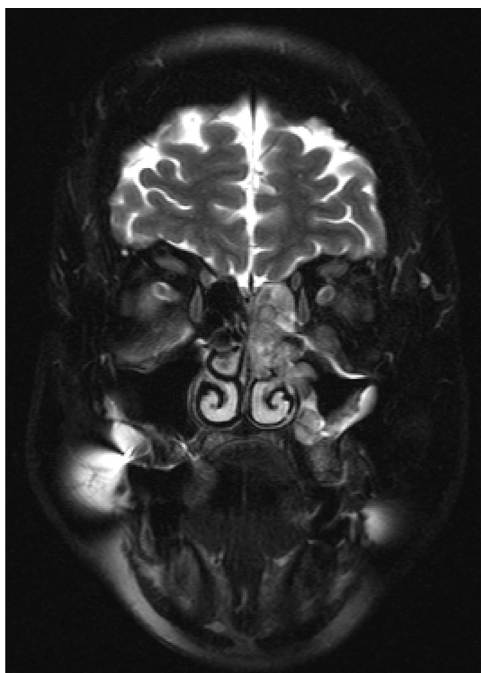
Contrast-enhanced T2-weighted magnetic resonance imaging image demonstrates a heterogeneously enhancing mass centered in the left nasal cavity with extension into the maxillary and ethmoid sinuses, biopsy-proven to be rhabdomyosarcoma.
